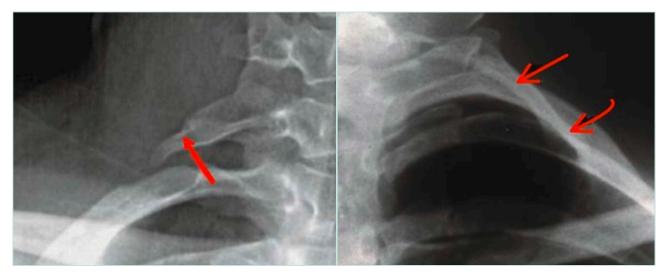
X-ray with elongated transverse process (right image) and complete cervical rib (left image).
